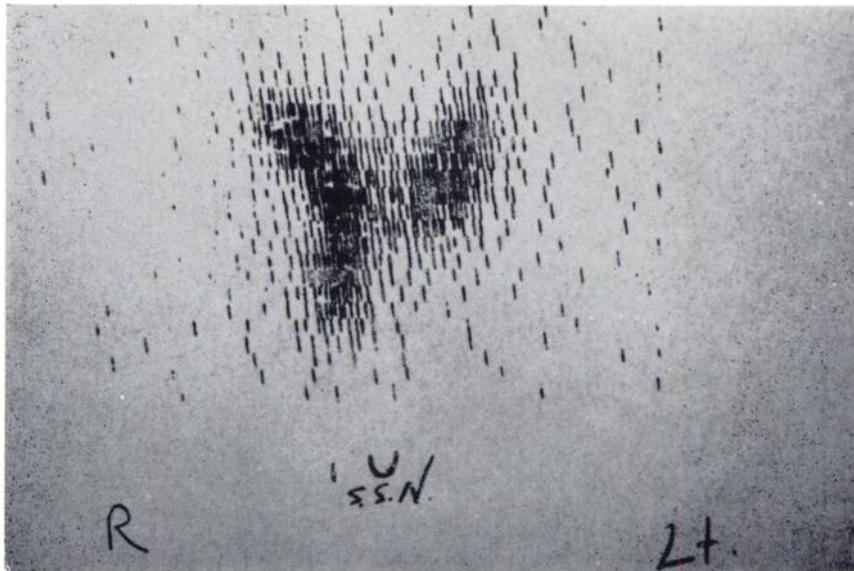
Case IV  $I^{131}$  scintigram after  $I^{131}$  therapy revealing restored function in previously suppressed normal thyroid tissue.
